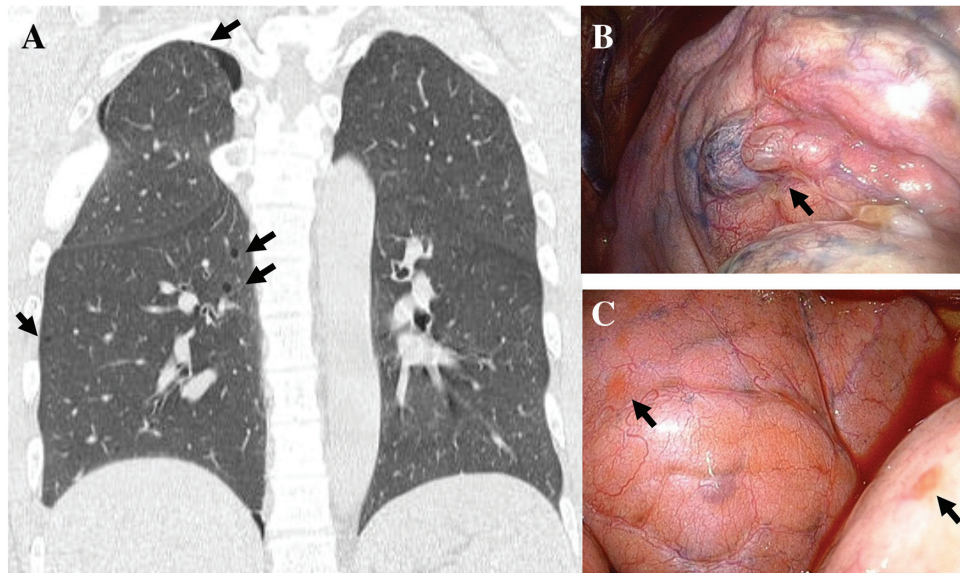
(A) A coronal section of Chest CT. There are a lot of small cysts with thin cystic wall (arrows). (B) Thoracoscopic findings. There are projecting bullae with anthracosis on the right S1 (arrows). (C) Thoracoscopic findings. There exists reddish, small and flattened bullae on the right middle and lower lobe (arrows).
